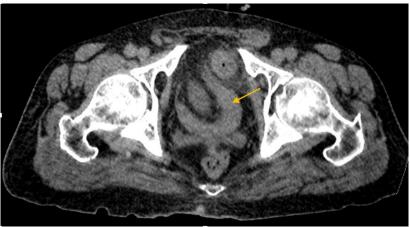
Abdominal CT scan revealing a supravesical hernia with intestinal contents located in the Retzius space, exerting a mass effect on the bladder, creating the "bull's horn" appearance (arrow)
